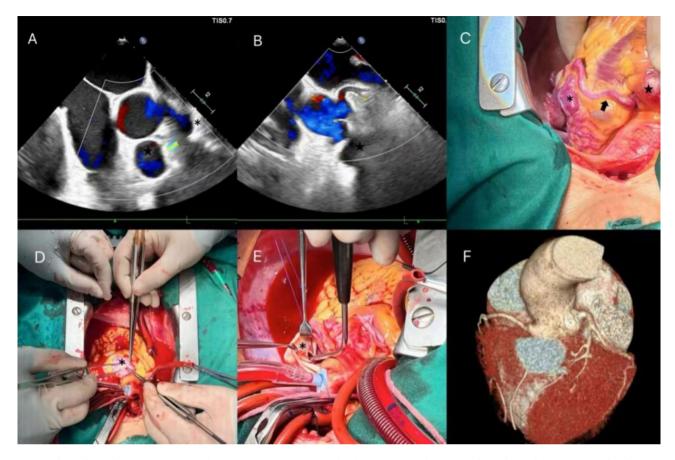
Echocardiographic, intraoperative and postoperative CTA images in the above-mentioned patients. Echocardiographic images (A and B) showing the right and left coronary artery aneurysms (CAAs). Intraoperative imaging (C-E) showing resection of the right and left CAAs. Reconstruction images of postoperative CTA (F) showing the complete resection of CAAs.
